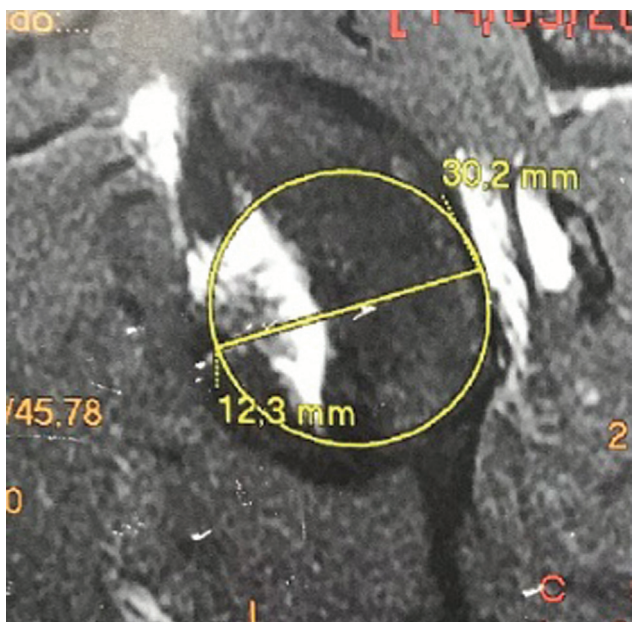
Sagittal T2-weighted magnetic resonance imaging scan showing glenoid bone defect.
